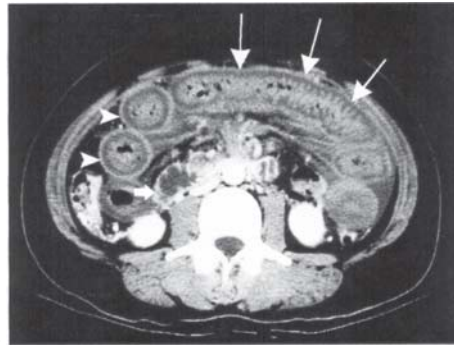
CT scan: pneumatosis intestinalis (arrows)*
